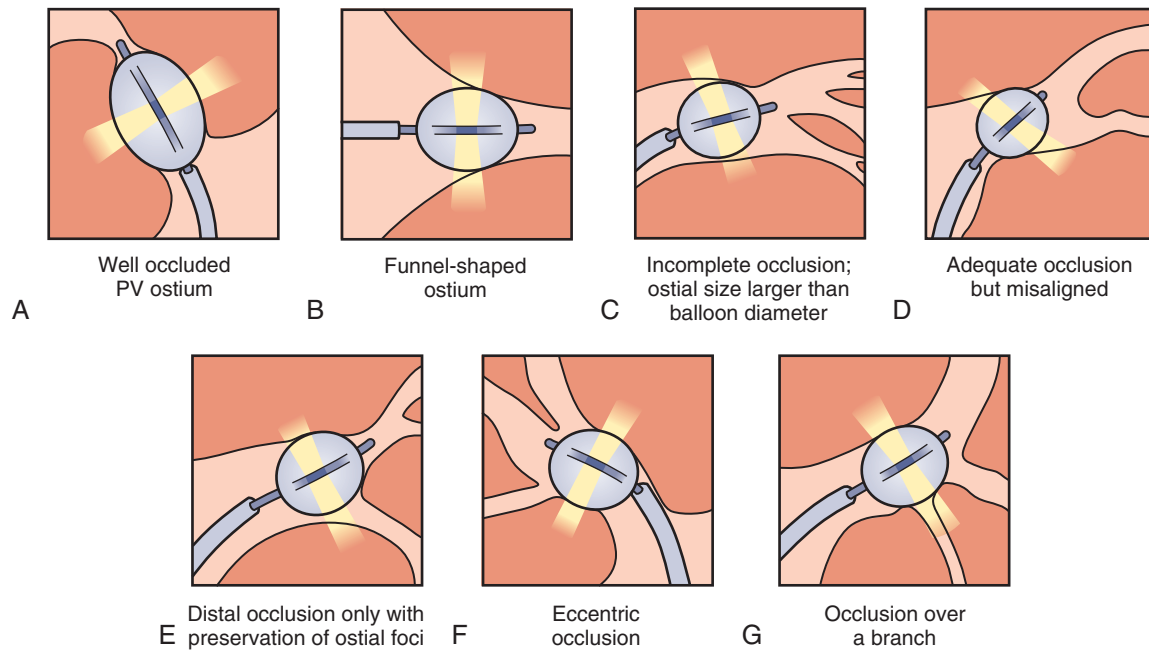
Some anatomic variants that are potentially responsible for ineffective delivery of ultrasound lesions. A, Well-occluded pulmonary vein (PV) ostium. B, Funnel-shaped ostium. C, Incomplete occlusion in which ostial size is larger than balloon diameter. D, Adequate occlusion but misaligned. E, Distal occlusion only with preservation of ostial foci. F, Eccentric occlusion. G, Occlusion over a branch. (Modified from Saiba W, Wiber D, Packer D, et al: Circumferential ultrasound ablation for pulmonary vein isolation: Analysis of acute and chronic failures, *J Cardiovasc Electrophysiol* 13:957–961, 2002.)
